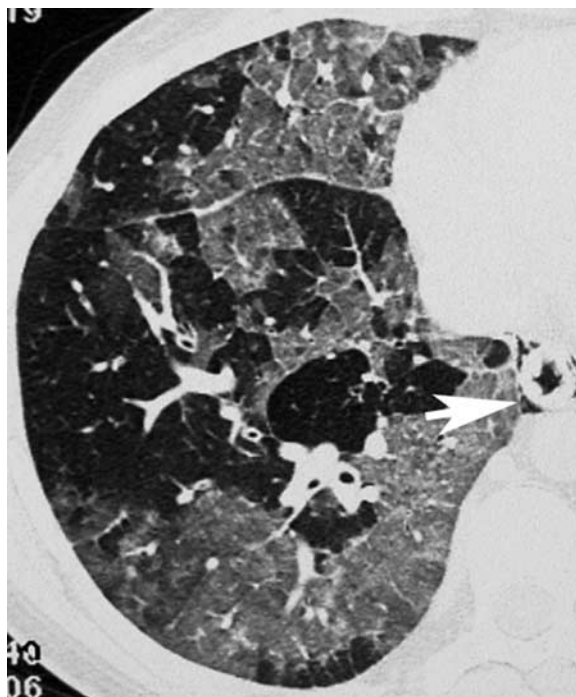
Pneumocystis jirovecii* pneumonia in AIDS. HRCT of a 34-year-old man with acquired immunodeficiency syndrome shows bilateral ground-glass opacities interspersed by normal lung parenchyma. Also note a pneumomediastinum (arrow). HRCT indicates high-resolution CT.
